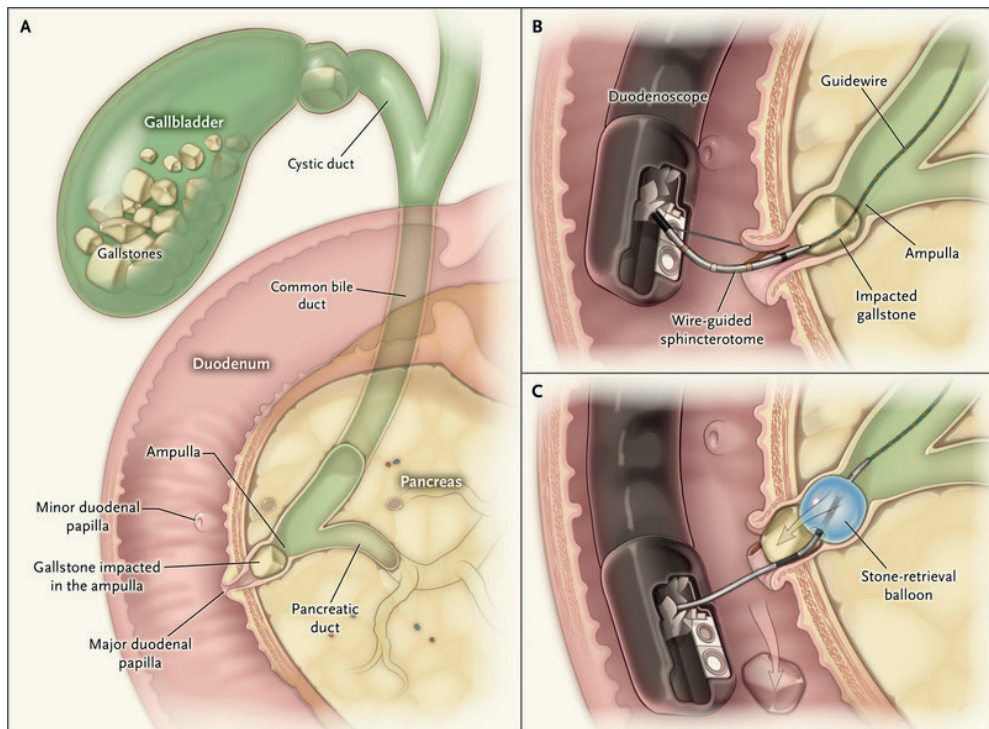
ERCP is a procedure developed to diagnose and treat diseases of the pancreatobiliary system. During the procedure, a flexible endoscope is passed through the mouth, esophagus and stomach into the duodenum to reach Vater's papilla. In the papilla the pancreatic duct and common bile duct pass into the duodenum. Using contrast injection and X-ray the pancreatobiliary system is visualized. A range of instruments is available to perform treatment such as endoscopic sphincterotomy or bile duct clearance during ERCP.¹²
